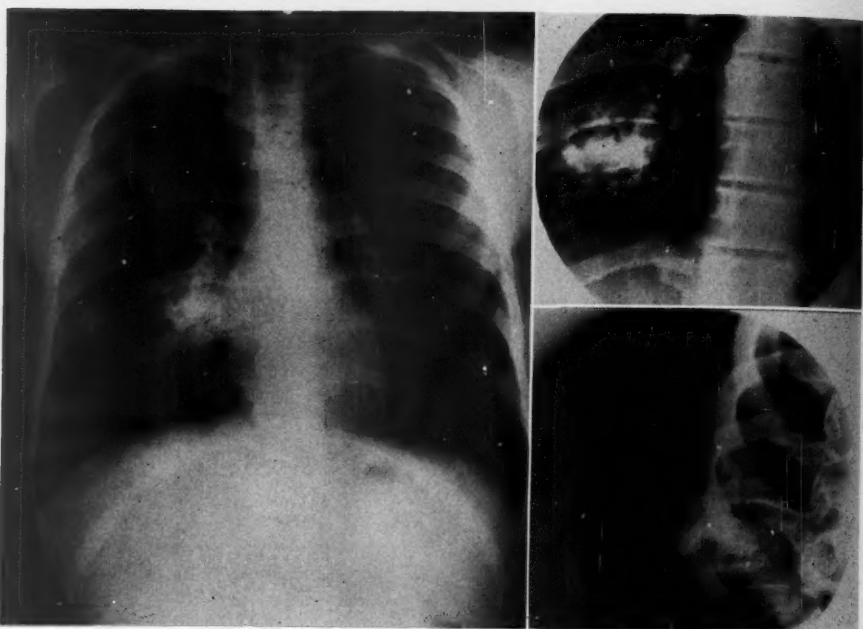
Roentgenograms of the chest showing (left) an irregular mass opposite the right hilum, (top right) calcification in the mass which appears to be in the chest wall, and (bottom right) definite origin in the bony chest wall.
